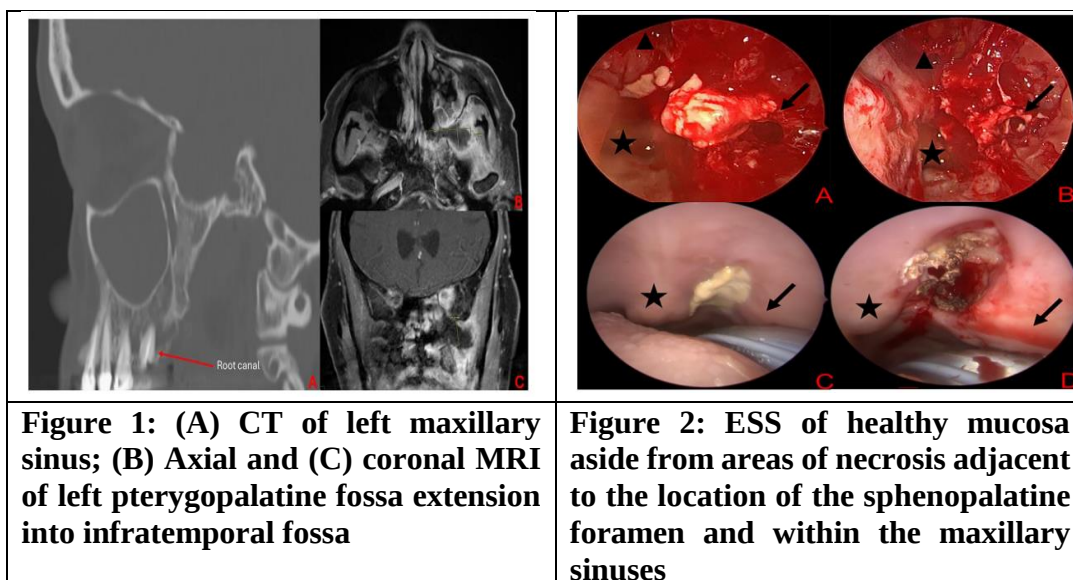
(A) CT of left maxillary sinus; (B) Axial and (C) coronal MRI of left pterygopalatine fossa extension into infratemporal fossa
